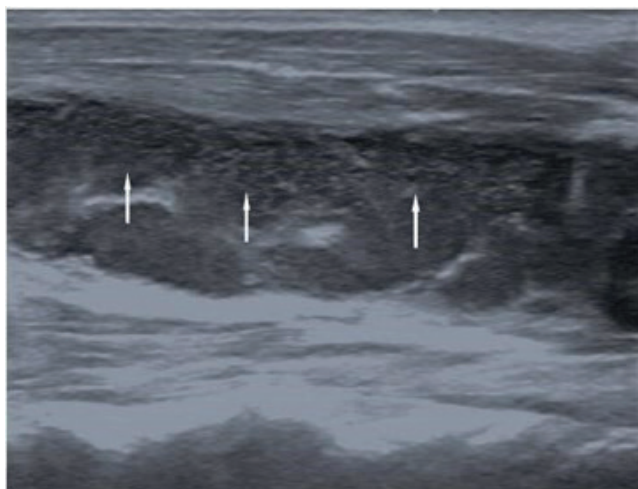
Gray scale ultrasound images of the cervical region
